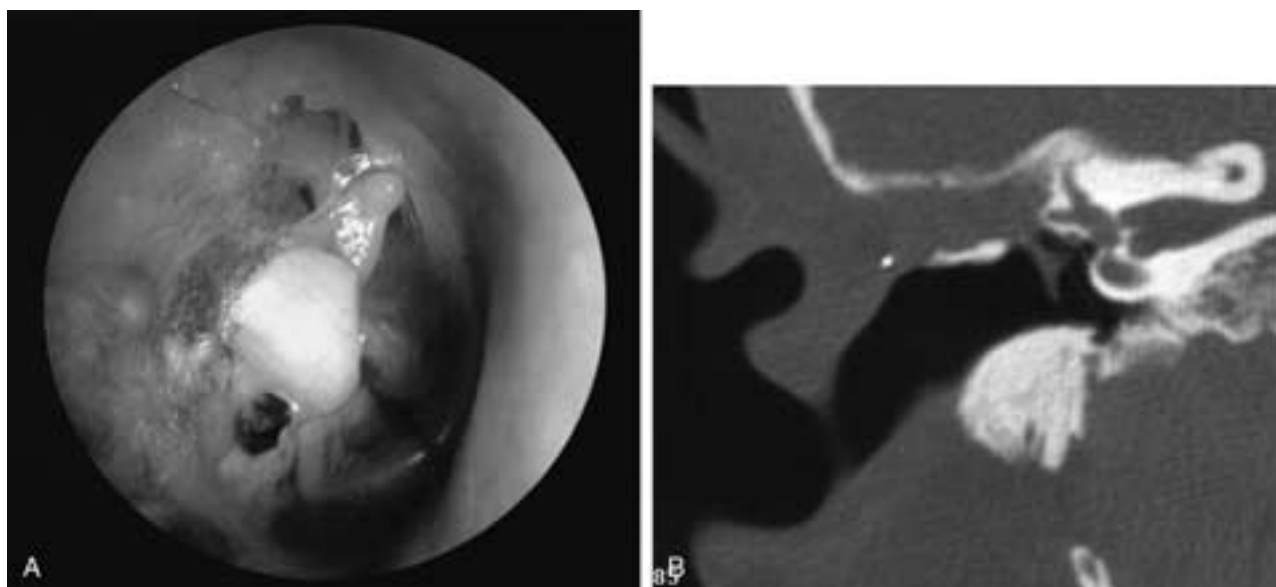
Carilage PORP. A, Otoscopy. B, Coronal CT shows PORP articulating with the tympanoplasty and extending toward the oval window. The stapes is often difficult to visualize.
